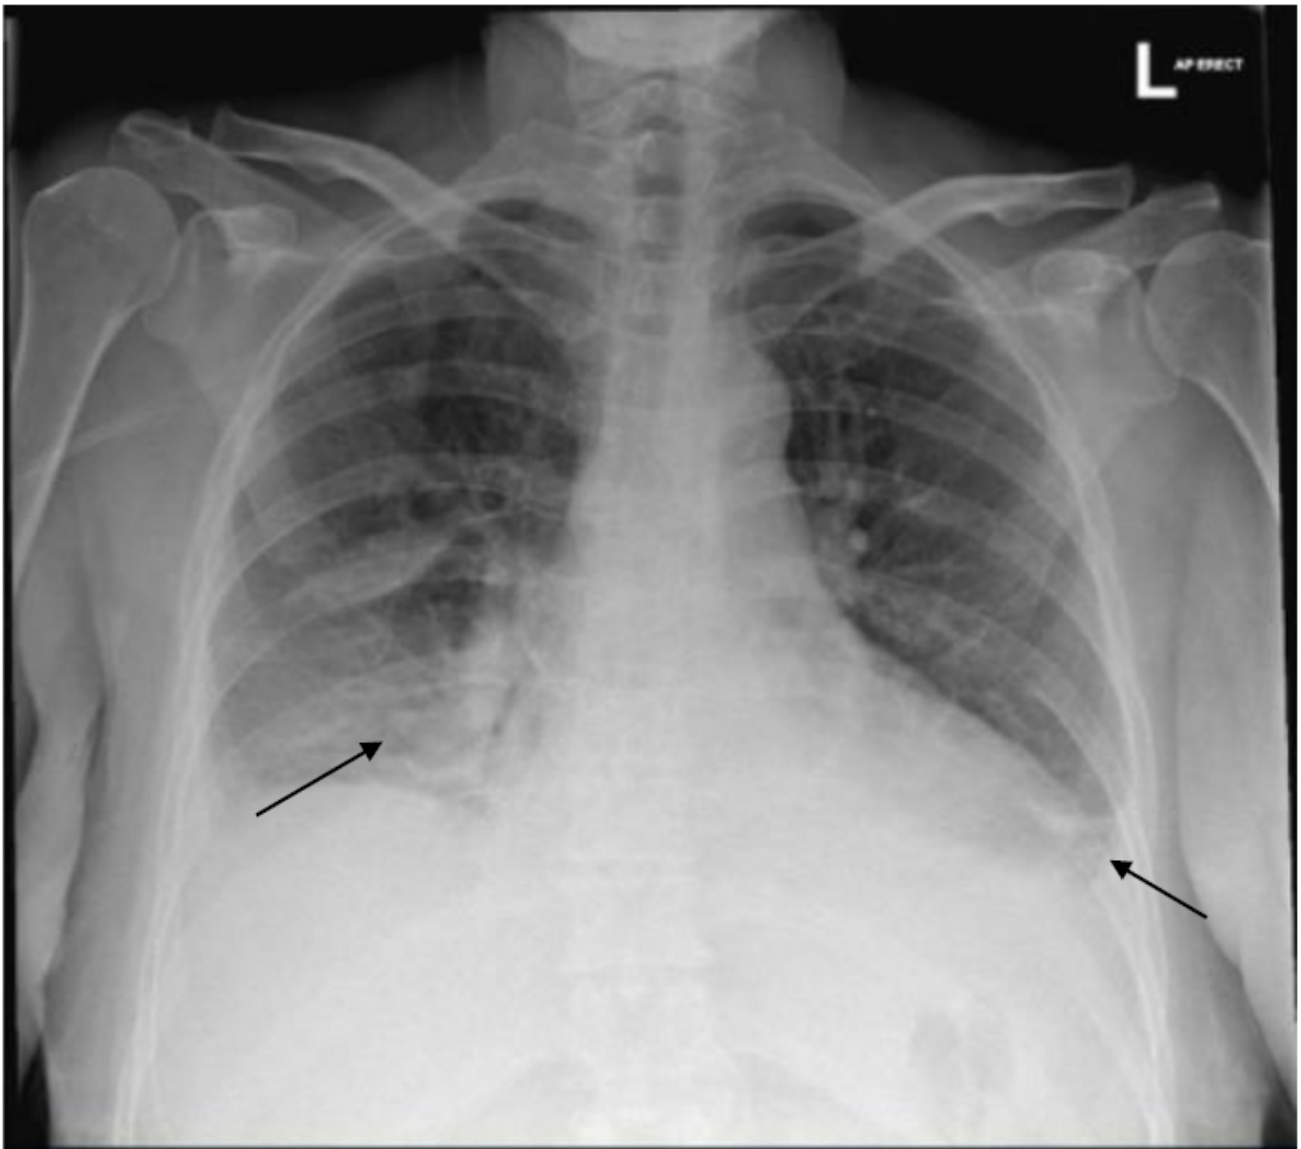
Chest X-ray on admission demonstrating bilateral lower zone opacification, as demonstrated by the arrows.
